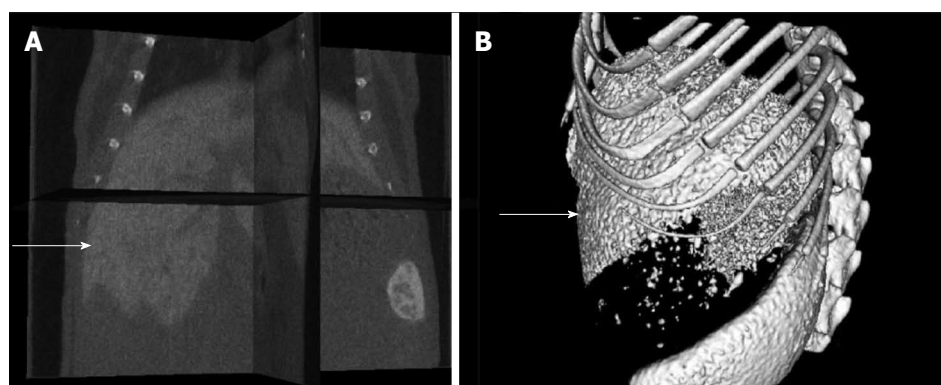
Contrast enhanced computed tomography images of a normal liver. A: 3D image of a liver (arrow); B: Perspective view of a liver (arrow).
